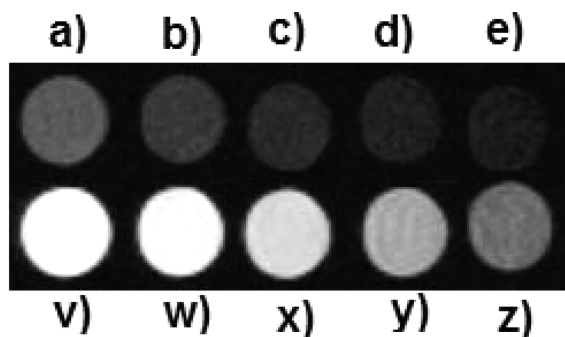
T_1 -weighted MR images of samples recorded at 1.0 T at 25 °C. Samples of Magnevist (a → e) and Gd₆H₃L (v → z) containing a series of decreasing concentrations from 0.4 mM, 0.2 mM, 0.1 mM, 0.04 mM, to 0.02 mM.
